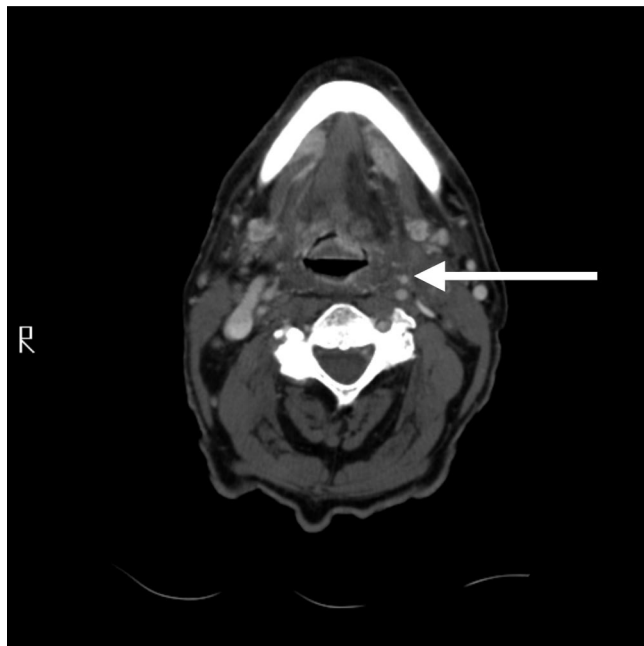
Arrow points to persistent left-sided cervical adenopathy on computed tomography scan 2 weeks after therapy.
